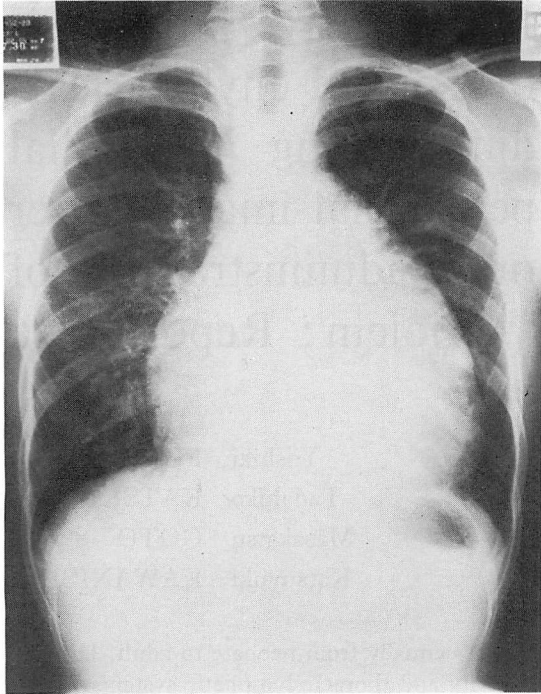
Chest roentgenogram showing moderate cardiomegaly with water bottle configuration.
